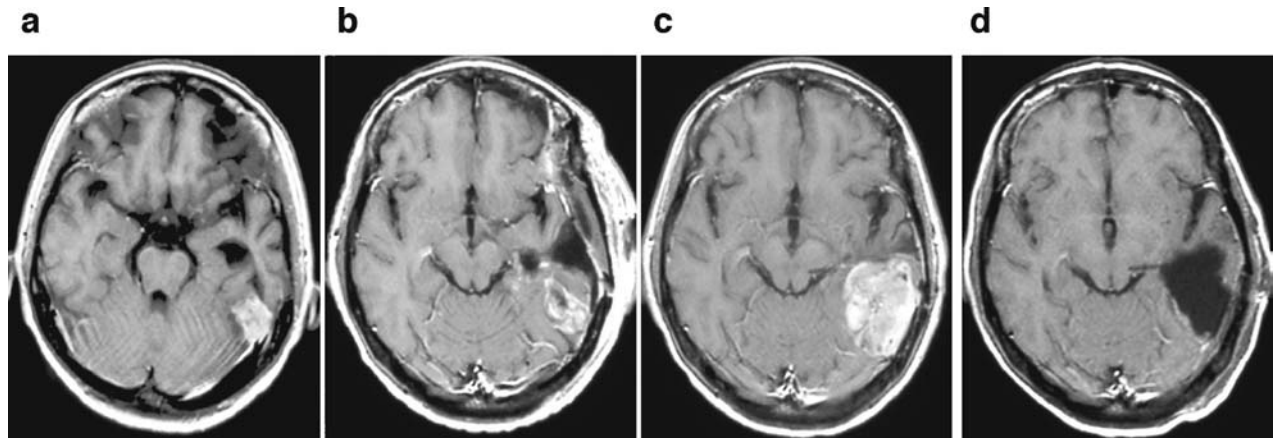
T1-weighted magnetic resonance images with gadolinium-diethylenetriaminepenta-acetic acid. Before the operation, a solid enhanced lesion was located in the posterior portion of the inferior temporal gyrus (a). Anterior temporal lobectomy and partial resection of the enhanced lesion was performed (b). Sixteen months after the partial resection, the enhanced mass had enlarged (c). Gross total removal of the tumour was confirmed after the second operation (d)
